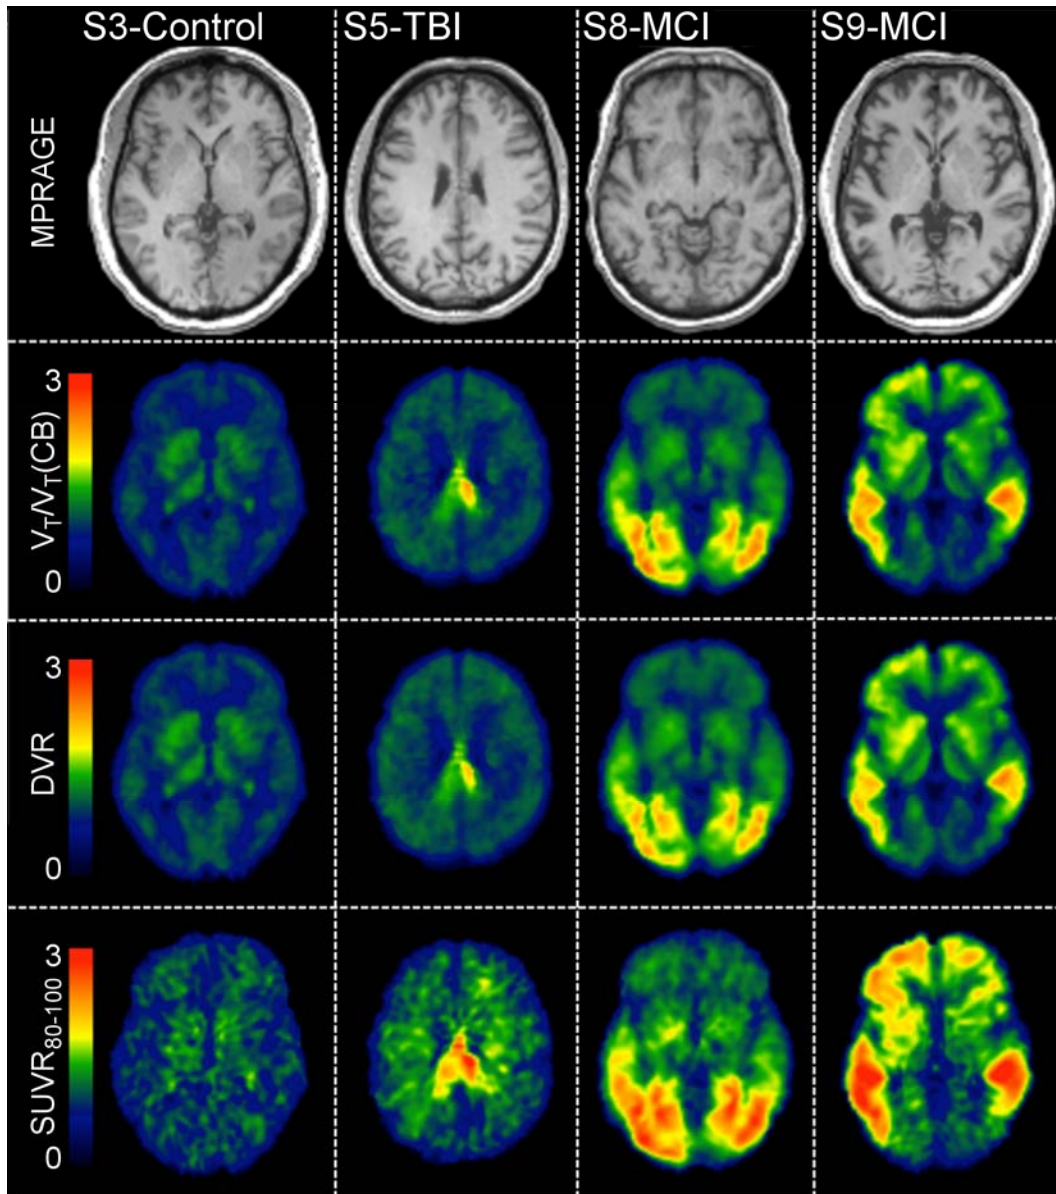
MPRAGE in template space and parametric images of indirect calculation of DVR using Logan ( $V_T/V_T(CB)$ ), Logan DVR, and SUVR in a control subject (S3), a subject with history of traumatic brain injury (S5), and two subjects with MCI (S8 and S9).
